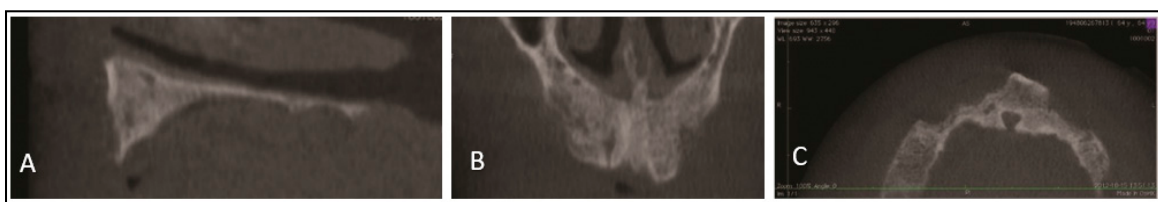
Cone beam computed tomography (CBCT) analysis before surgical treatment showed severe bone atrophy in the pre-maxilla area: (A) sagittal view, (B) coronal view and (C) axial view.
